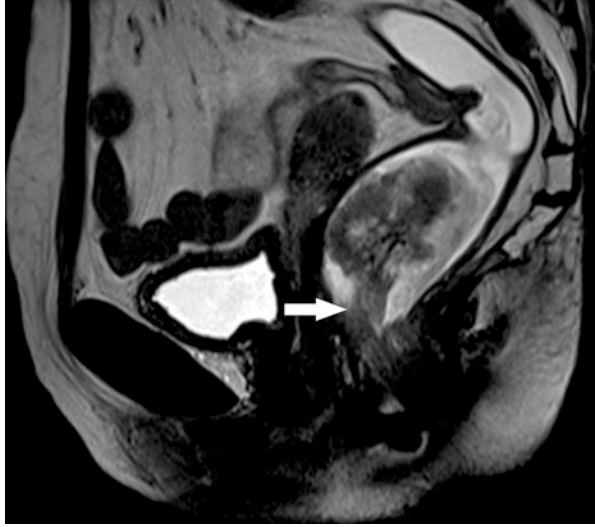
Axial T2-weighted MR image showing eccentric wall thickening confined to bowel wall, i.e., T2 lesion (white arrow)
